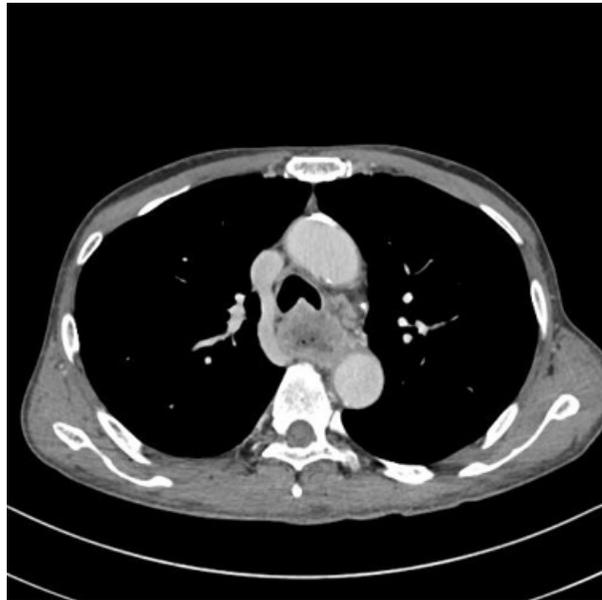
Contrast CT showed mid esophageal lesion.
